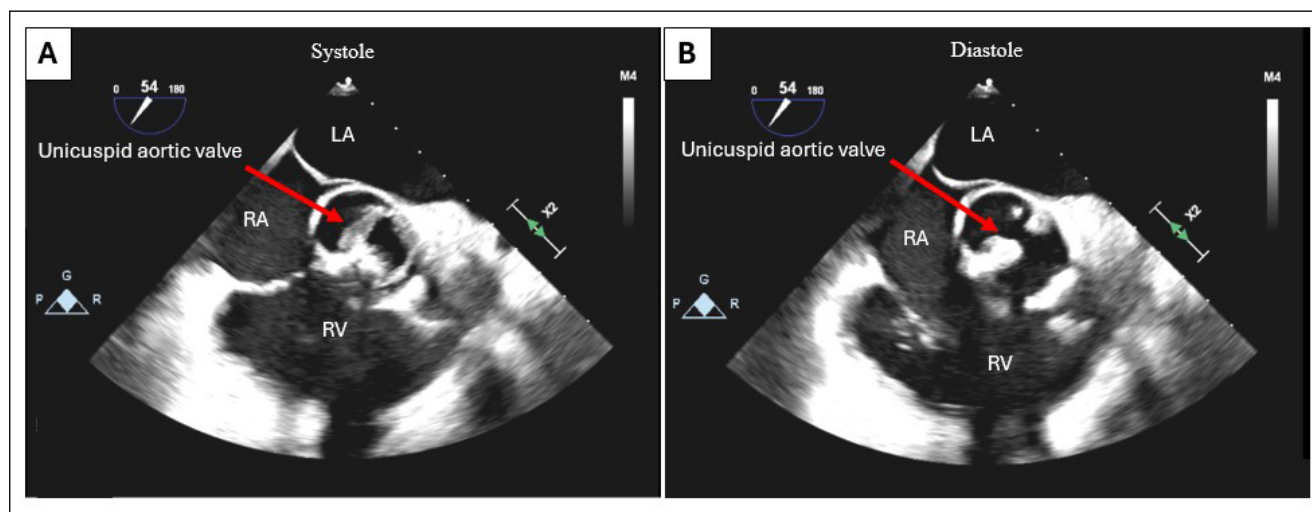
Intraoperative transesophageal echocardiogram in 2-dimensional short-axis view showing calcification of the aortic valve with severe aortic stenosis. (A) At systole: aortic valve open; (B) at end diastole. RV: right ventricle, LA: left atrium, RA: right atrium
